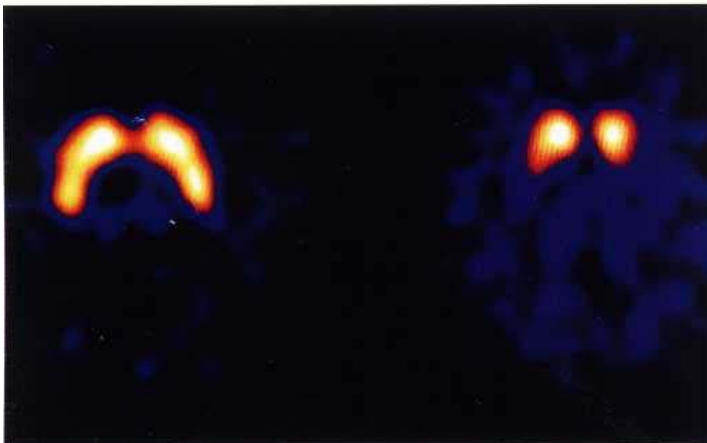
^{123}I -beta CIT SPECT imaging showing normal distribution of activity in a patient with essential tremor (A) and diminished putamen and caudate uptake in a patient with Parkinson's disease (B). (Courtesy of Dr M. Buxton-Thomas.)
